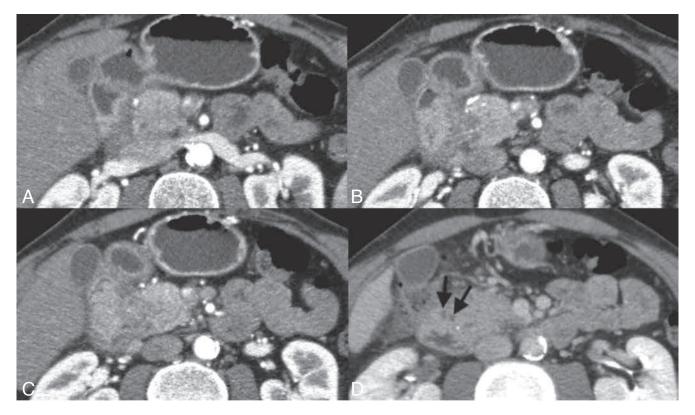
Arterial (A-C) and venous (D) phase CT-scan in a 49-year old man with segmental groove pancreatitis. Images from cranial to caudal show a sheetlike hypodense mass in the groove between the pancreatic had and the duodenum (A). Extension can be seen in the pancreatic head and the swollen pancreatic head can not be clearly delineated from the lesion in the groove area (B-C). The duodenal wall is thickened and contains several small cysts (black arrows) (D).
